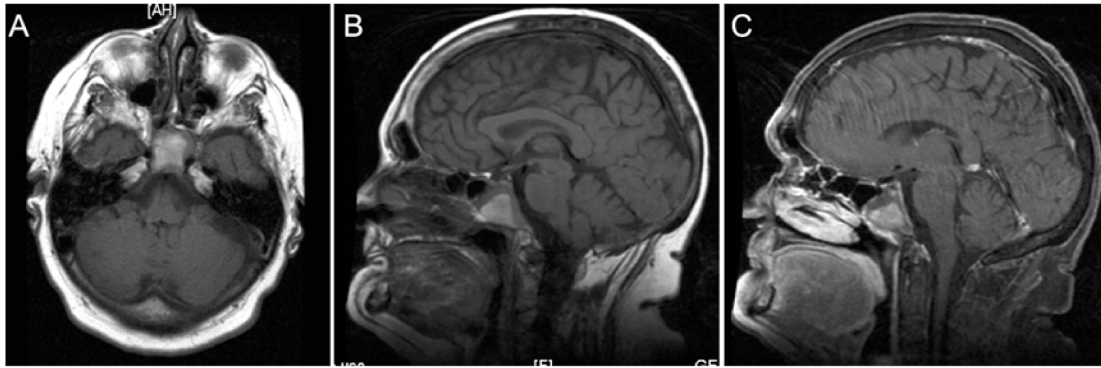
MRI from a 64 year-old woman with headaches showing a erosive lesion in the clivus. T1-weighted axial (A) and sagittal (B) images show a mixed signal intensity lesion in clivus with a hyperintense in central core surrounded by an area of hypointense signal. (C) Peripheral enhancement is shown on post-gadolinium T1-weighted sagittal image.
